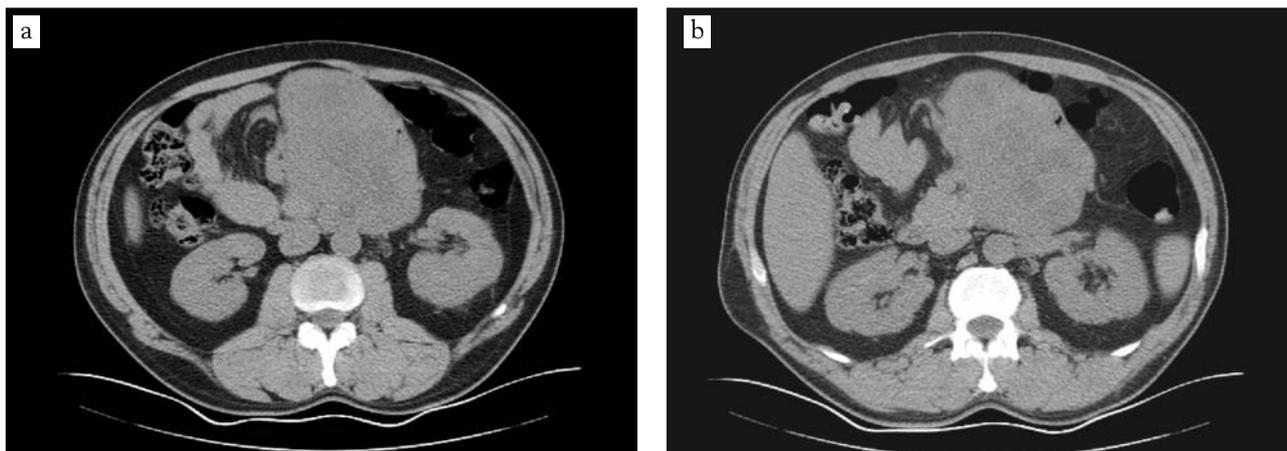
a: Abdominal CT scan: giant tumor developed in the mesentery of duodenojejunal junction
